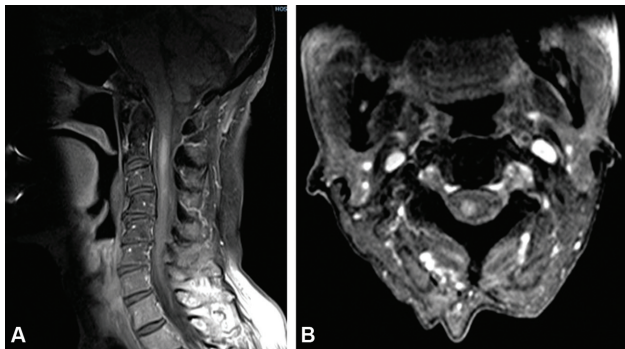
(A) Five days after corticotherapy: sagittal T1 postcontrast magnetic resonance imaging (MRI). (B) Five days after corticotherapy: axial T1 postcontrast MRI.
